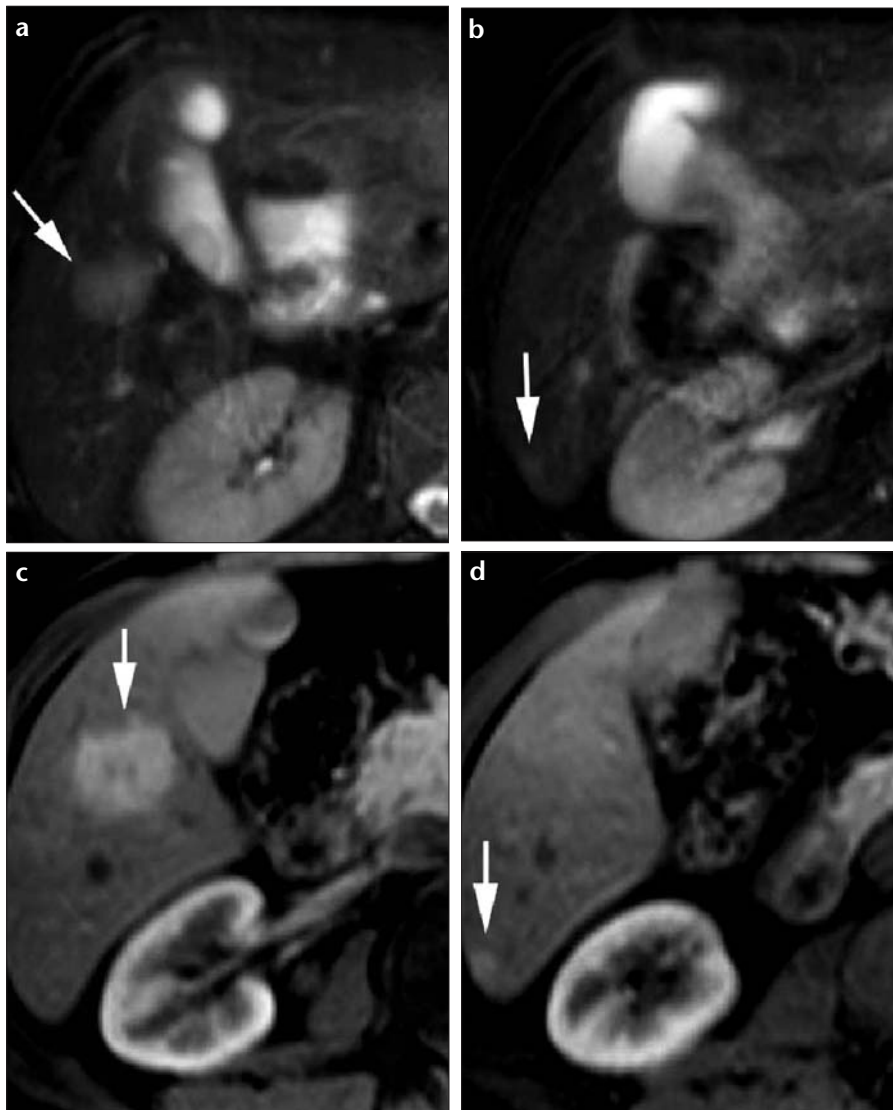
a-d. Metastases of neuroendocrine carcinoma. Transverse fat-saturated TSE T2-weighted MR images (a, b) show two moderately hyperintense lesions in hepatic segments 5 and 6 (*arrows*). On transverse post-contrast fat-saturated T1-weighted images taken in the arterial phase (c, d), diffuse, homogenous contrast enhancement of the lesions is seen.
